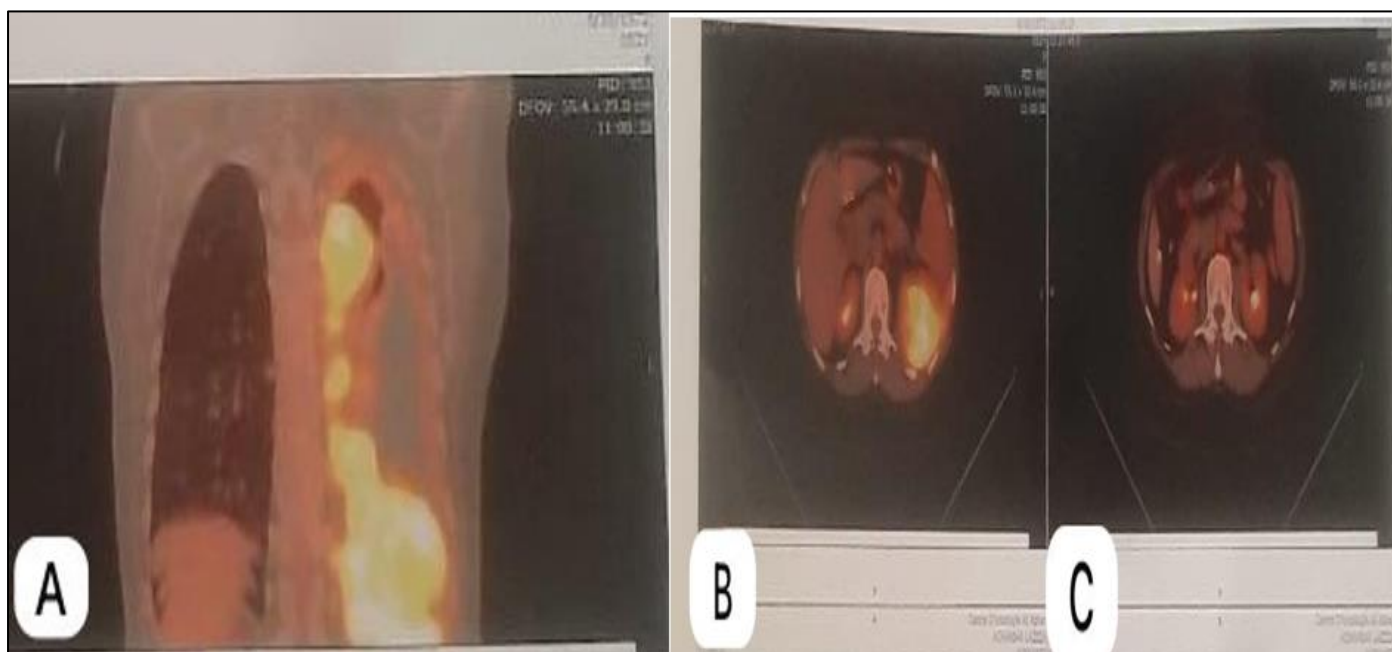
A : Intense FDG Uptake in the Left Hemithorax, Corresponding to the Postero-Lateral Pleura. B : Well-Localized FDG Uptake at the Postero-Lateral Aspect of the Left Pleura. C : No Suspicious Hypermetabolic Activity in the abdominal Organs, Adrenal glands, or Kidneys.
